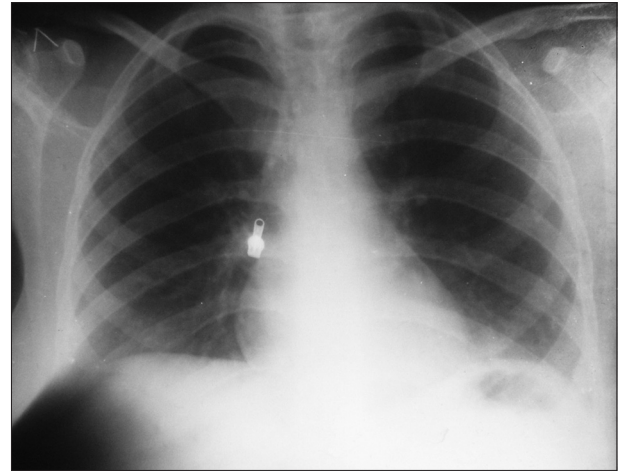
Post-delivery chest radiograph of the same patient showing resolution of eventration of diaphragm with normal position of the left dome at the left posterior 8th rib
